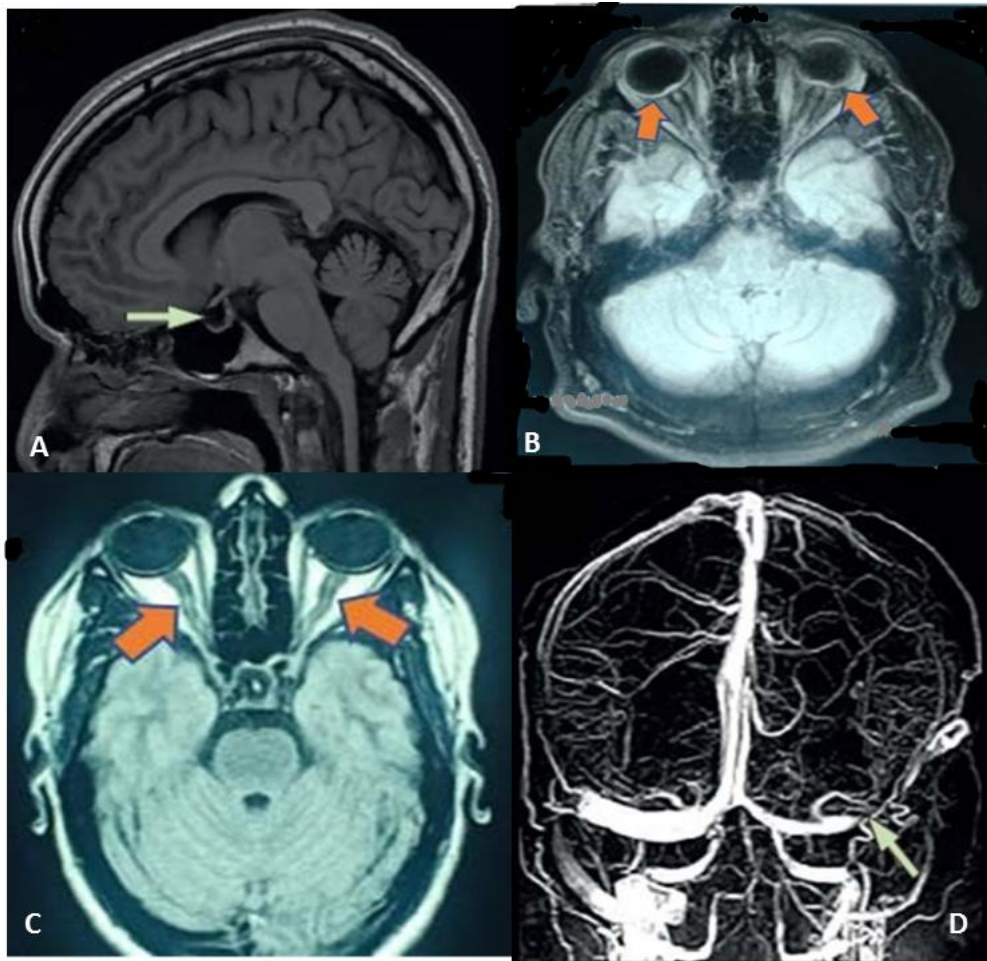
MRI indirect signs of intracranial hypertension:
